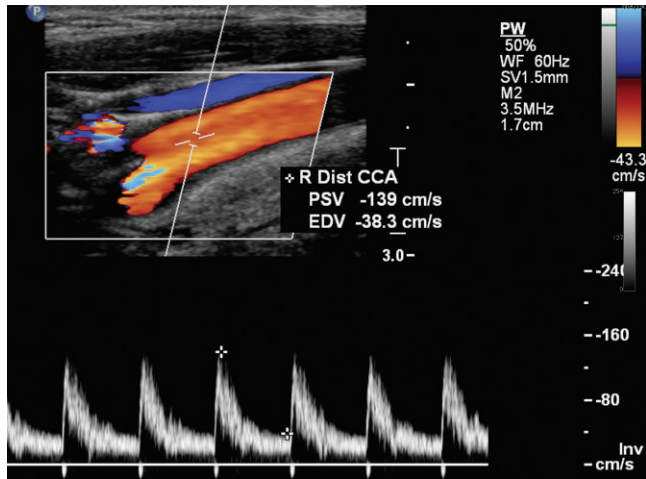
Spectral Doppler of the common carotid artery has a peak systolic velocity of 139 cm/s. This velocity is higher than usual. The common carotid is widely patent by color Doppler.
